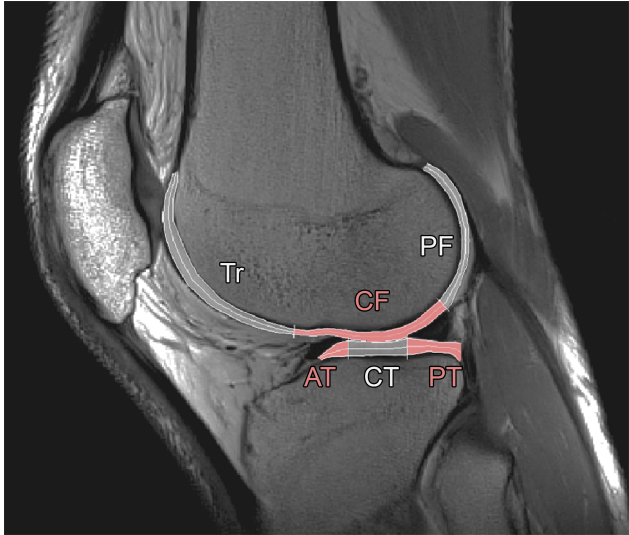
Segmentation of articular cartilage and ROI nomenclature [24] (Tr = Trochlea; CF = Central Femur; PF = Posterior Femur; AT = Anterior Tibia; CT = Central Tibia; PT = Posterior Tibia). Color has been introduced to help distinguish the regions.
